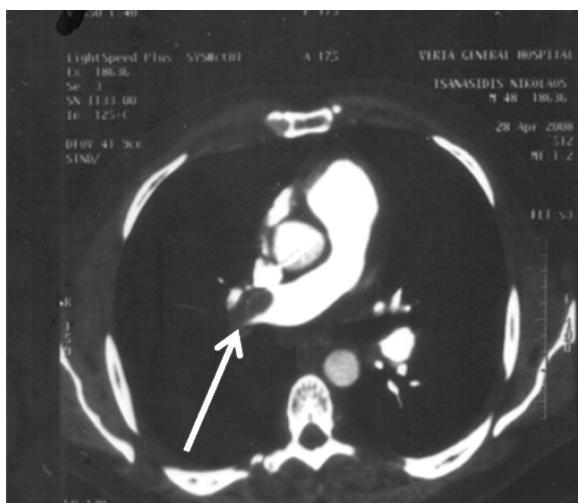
Chest CT scanning detects a large thrombus in the bifurcation of the pulmonary artery (arrow).
